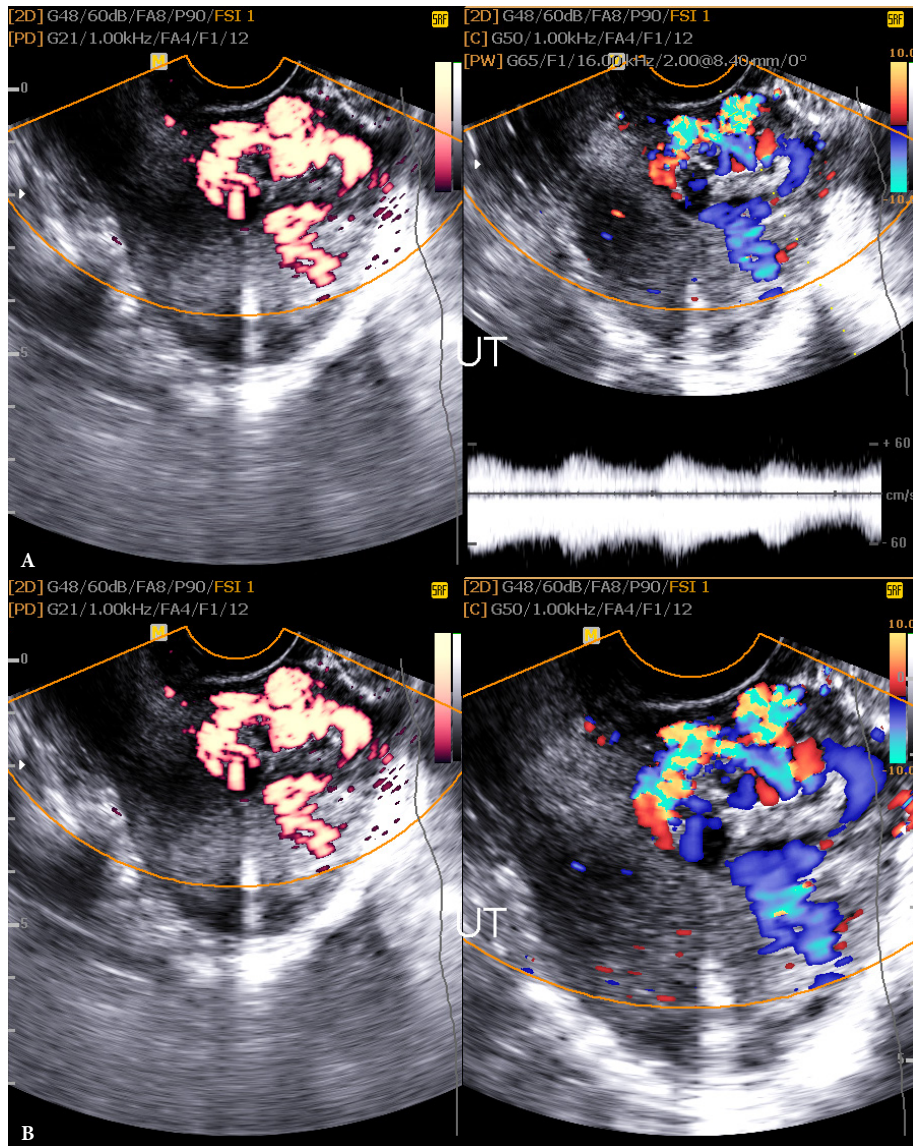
Transvaginal CD sonography examination showing multiple large anterior myometrial dilated, tortuous vessels with high velocity turbulent arterial flow and ectatic veins showing venous flow inside associated with normal endometrium suggesting arteriovenous malformation
